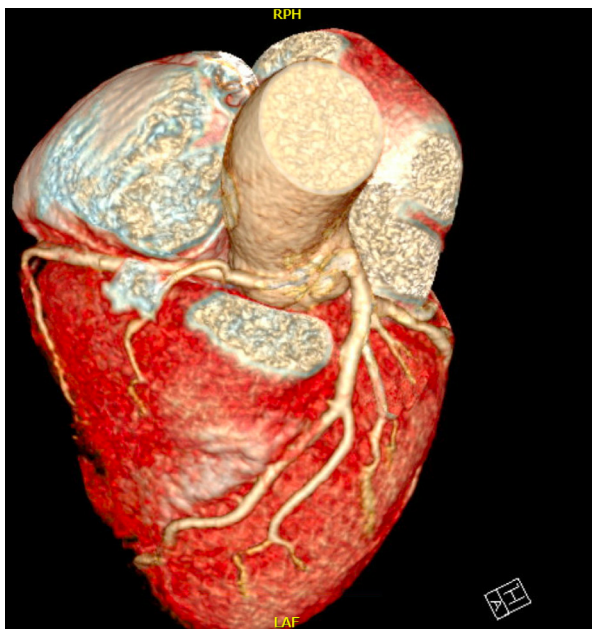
3D reconstruction from CTA demonstrating the ostia of right and left main coronary arteries are closely spaced with R coronary arising just left ward of the right/left commissure. There is an approximately 12 mm intramural and intraarterial course.
